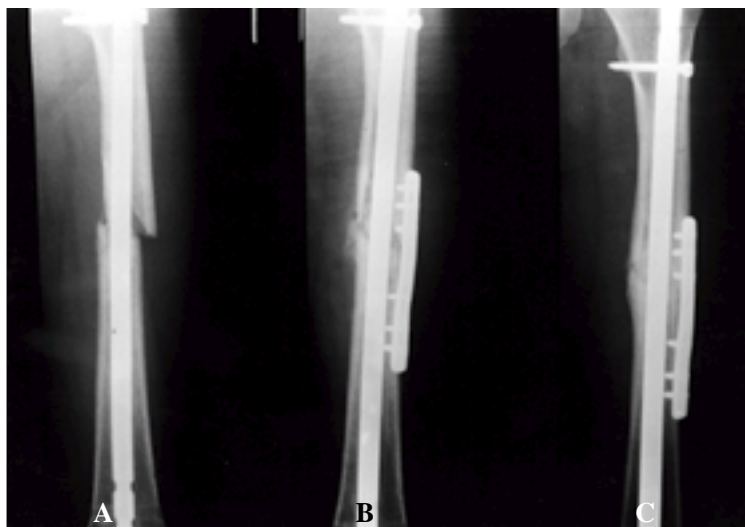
Radiograph taken at 13 months after intramedullary nailing shows atrophic nonunion.
